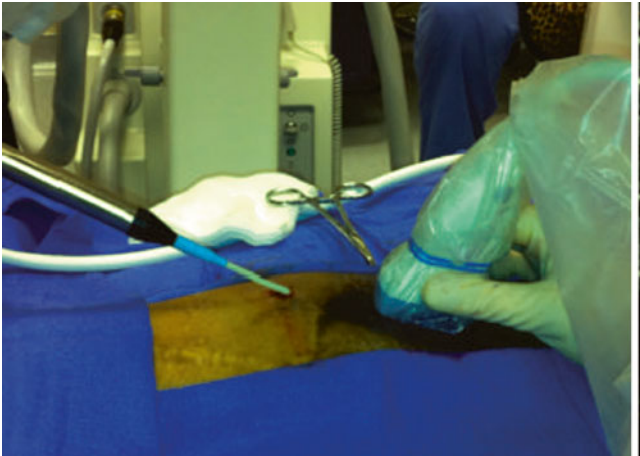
Ultrasound-directed cryoneuroablation of the sural nerve (From Rhame et al. [32]. Copyright © 2011 Ellen E. Rhame et al., reprinted with permission)
